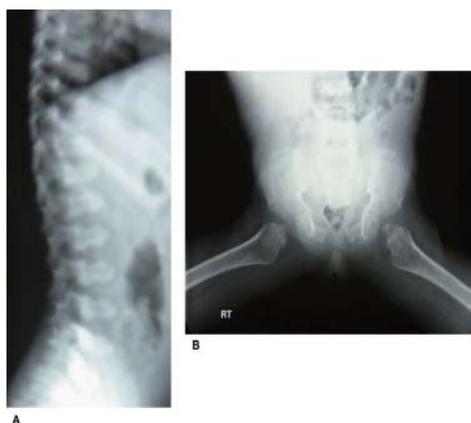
Radiological findings in case 8 with DMC syndrome at 10 years of age. X-ray (Lateral view) of thoraco-lumbar vertebrae showing platyspondyly with double constriction of lumbar vertebrae (A). X-ray of pelvis showing narrow pelvis, hypoplastic femoral heads and lace like appearance of iliac wings (B).
